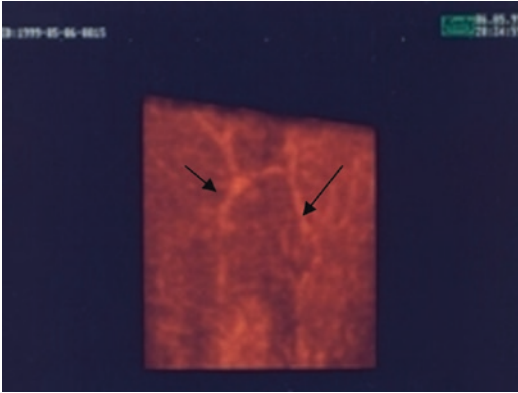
Echocolordoppler of the penis, showing the arterial vessels: corpus cavernosus arteries in 3D (arrow)
